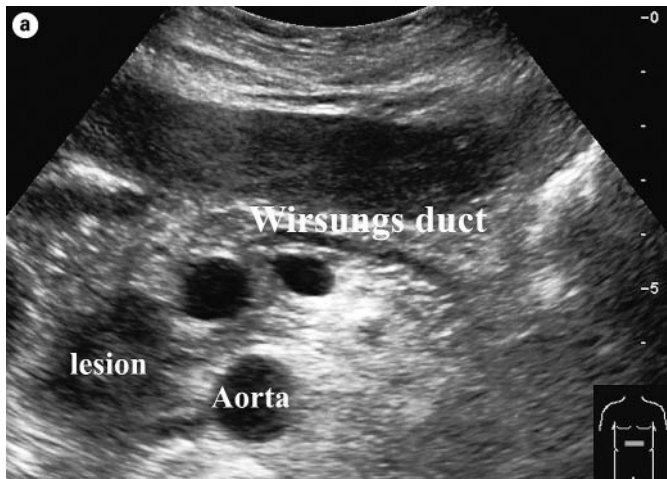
Ductal pancreatic carcinoma at conventional (a) and echo-enhanced sonography (b). a Low-echo tumor with lobulated margins and dilatation of Wirsung's duct. b Poorly vascularized lesion.
